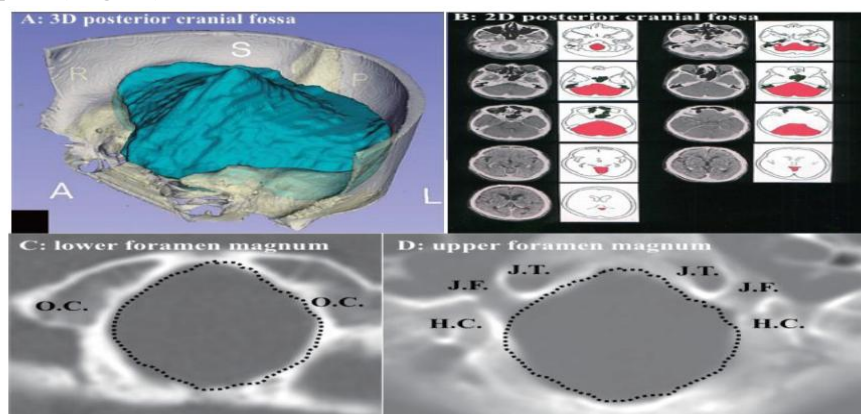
Volumetric analysis of the posterior cranial fossa (PCF). A: 3D-CT reconstruction. B: 2D-CT image with red areas indicating PCF volume (VPCF).
